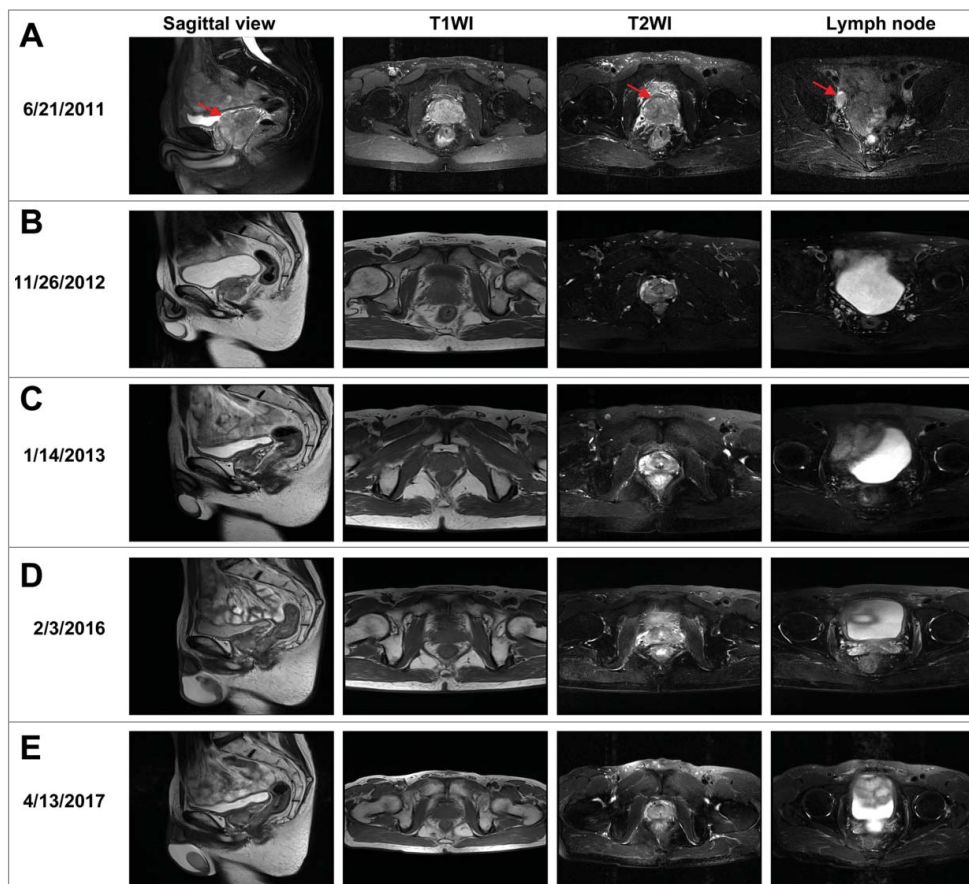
MRI scans of the patient before and after treatment for prostate cancer. (A–E) T1-weighted image (T1WI) and T2-weighted image (T2WI), as well as the sagittal view and lymph node images from T2WI from June 21, 2011 to April 13, 2017. Red arrows indicate the tumor in the prostate and lymph node metastasis.
